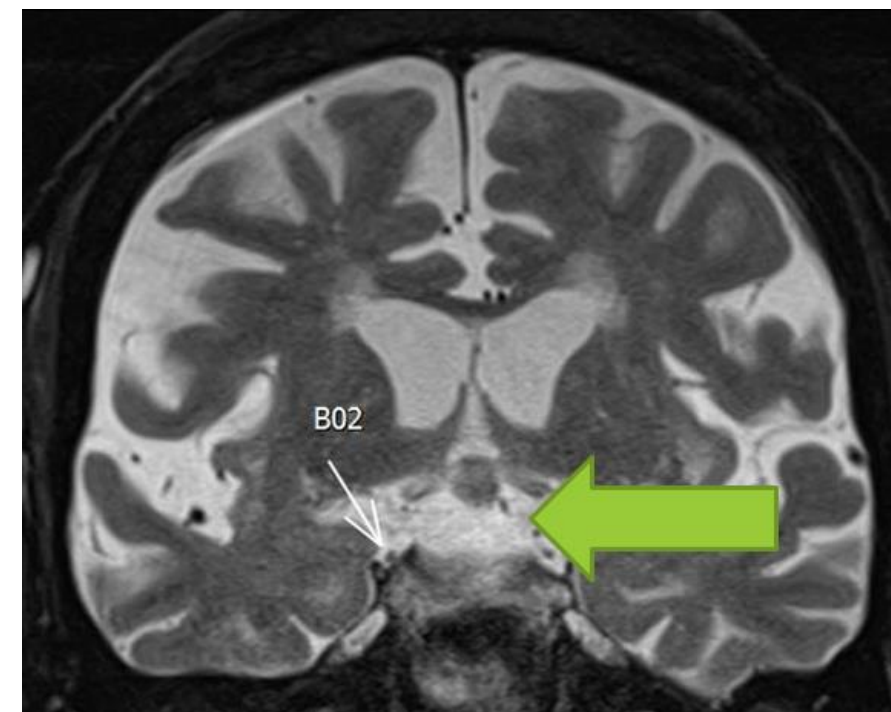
MRI brain obtained on HD 3 showing a pituitary macroadenoma measuring 2.5 cm abutting the right CN III and interval hemorrhagic transformation of the adenoma
